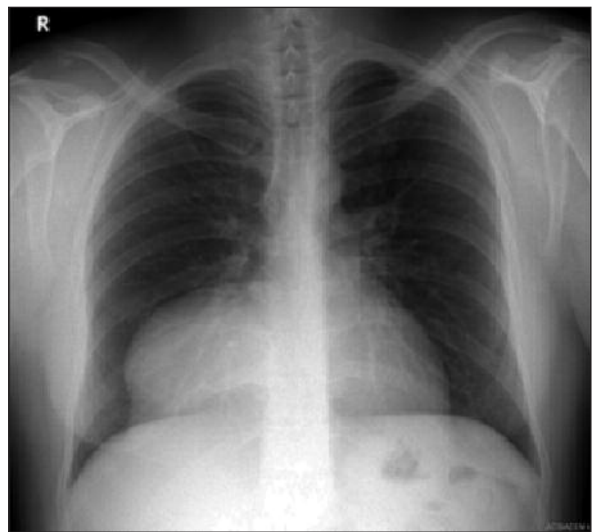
Preoperative posteroanterior direct chest x-ray image.
